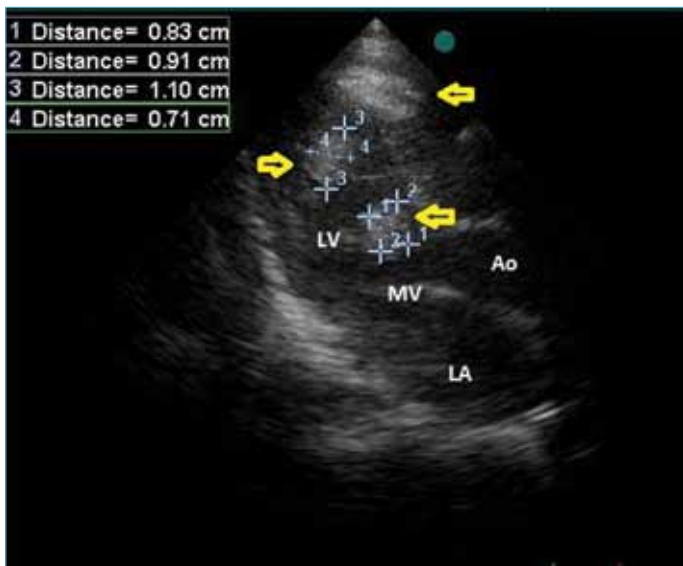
Echocardiographic image of case number 8
